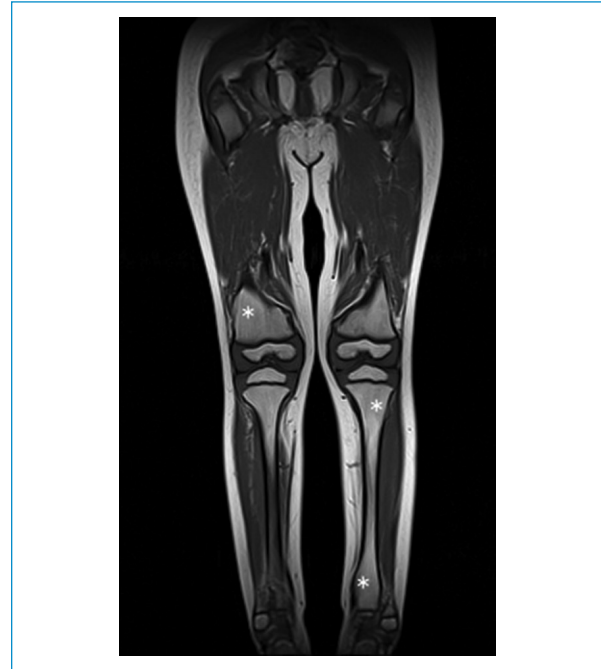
MRI coronal plane of the lower limbs showing multiple exostotic formations (white asterisks), highlighting the shape of the osteochondromas and its continuity from the cortical bone. This allows a direct study of the cartilage cap and the soft tissues surrounding the lesions
